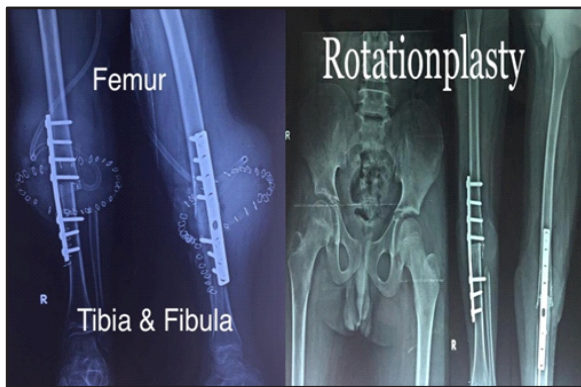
Immediate and follow-up radiograph of patient following rotationplasty surgery
